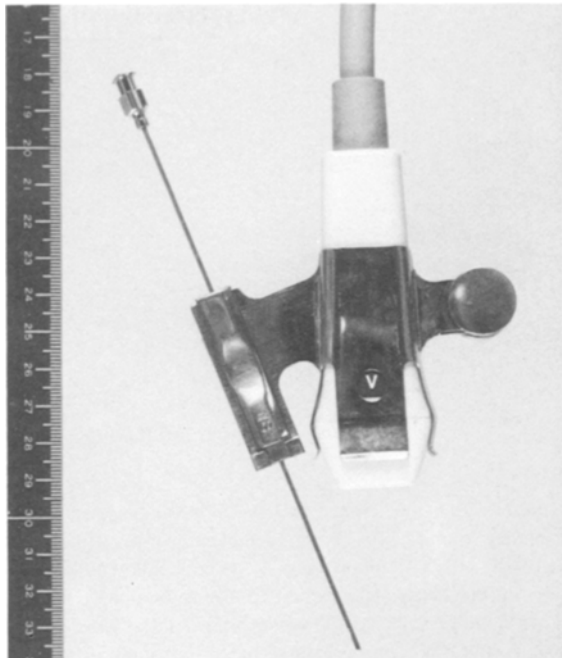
5 MHz sector-scanning ultrasonic transducer attached with a needle-guide apparatus which accommodates an extra-long 18-gauge ventricular needle. Size of the head measures 17.8×19.6 mm. The needling angle is fixed and corresponds to a guideline superimposed on the monitor cathode-ray tube screen
